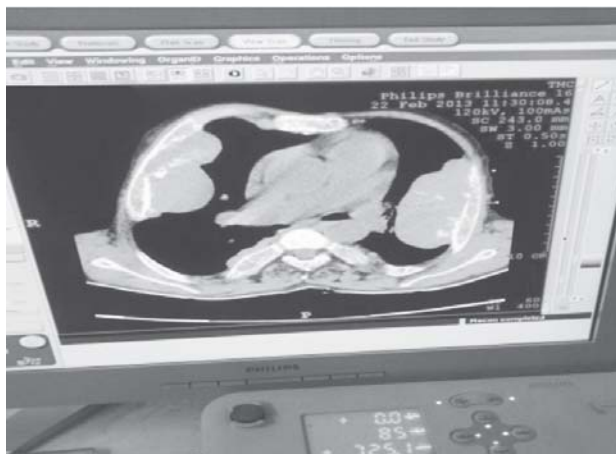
Contrast-enhanced CT of chest showed large mass at the lower lobe of both lungs
